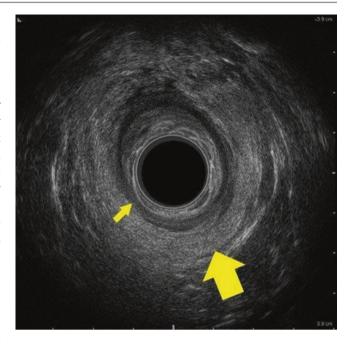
Two-dimensional endoanal ultrasonographic appearance of the mid-anal canal, highlighting the external anal sphincter (large arrow) and the internal anal sphincter (small arrow)
